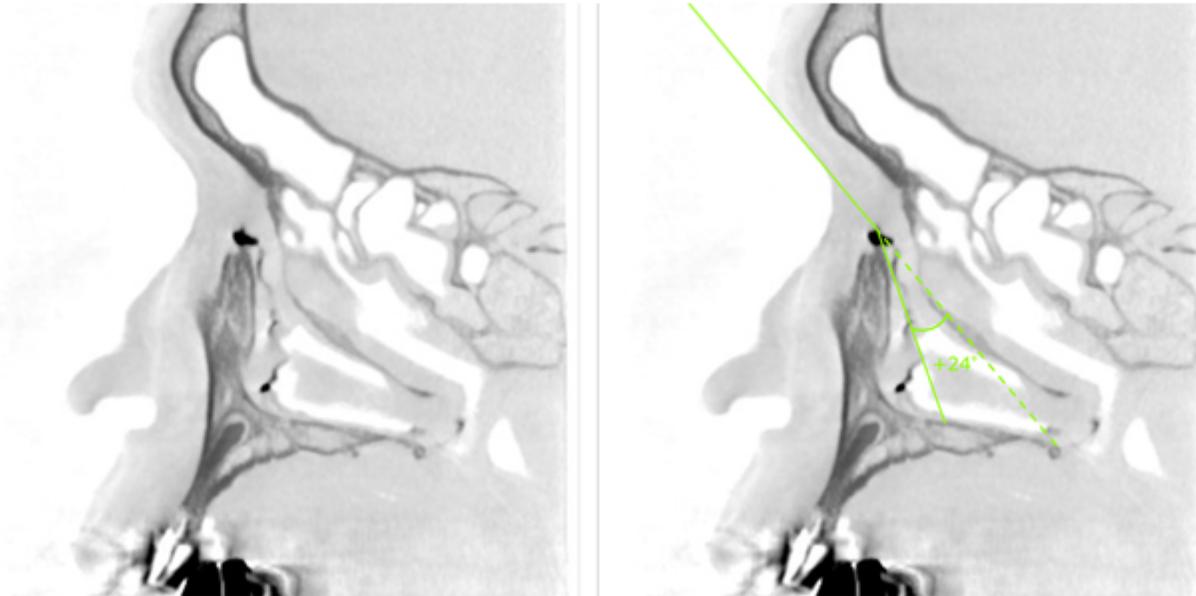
Abbreviations: CBCT-DCG, cone-beam computed tomography–dacryocystography.
